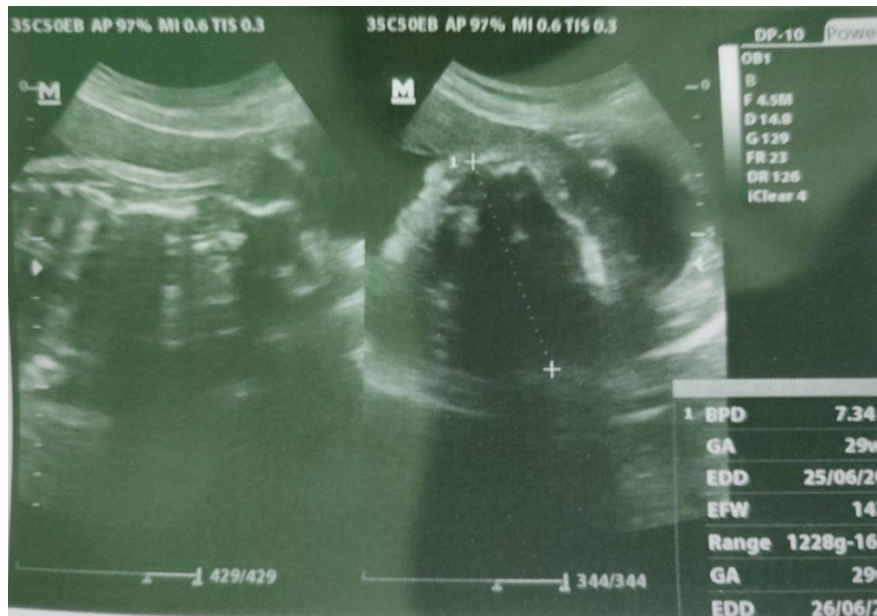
Ultrasound results showed anencephaly.
